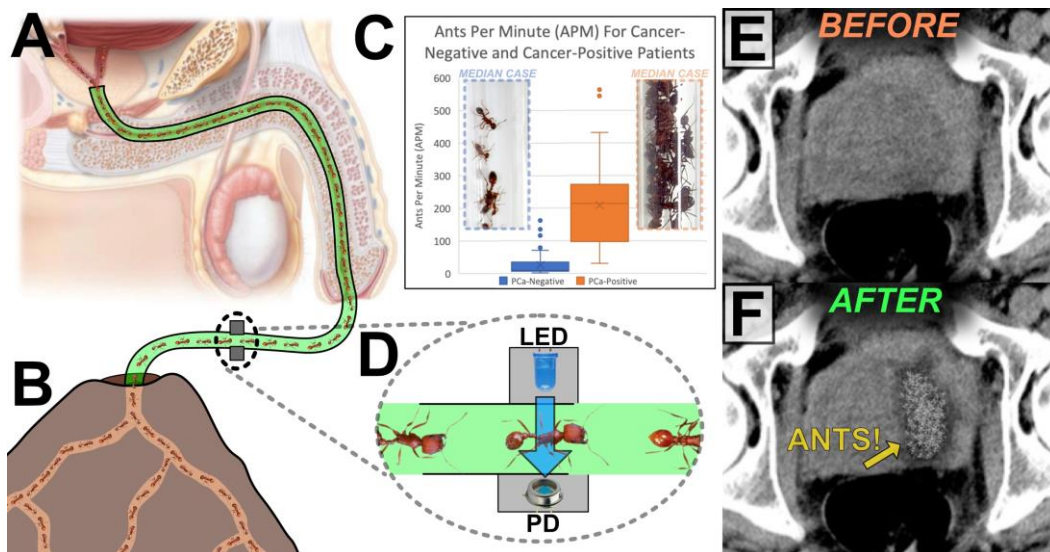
(A) catheter distal end in the verumontanum; (B) catheter proximal end in ant colony entry chamber; (C) ants per minute for PCa-positive and PCa-negative patients 5 minutes after catheter introduction, with representative photographs; (D) LED-photodiode used to estimate ants per minute (APM); (E-F) CT scan showing ant-mediated morcellation of tumor.
